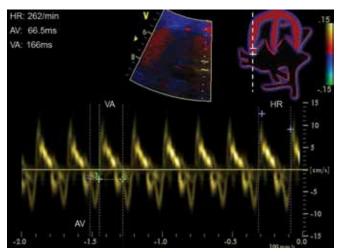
Tissue Doppler recording shows long VA supraventricular tachycardia which is well-known for its resistance to antiarrhythmic treatment
